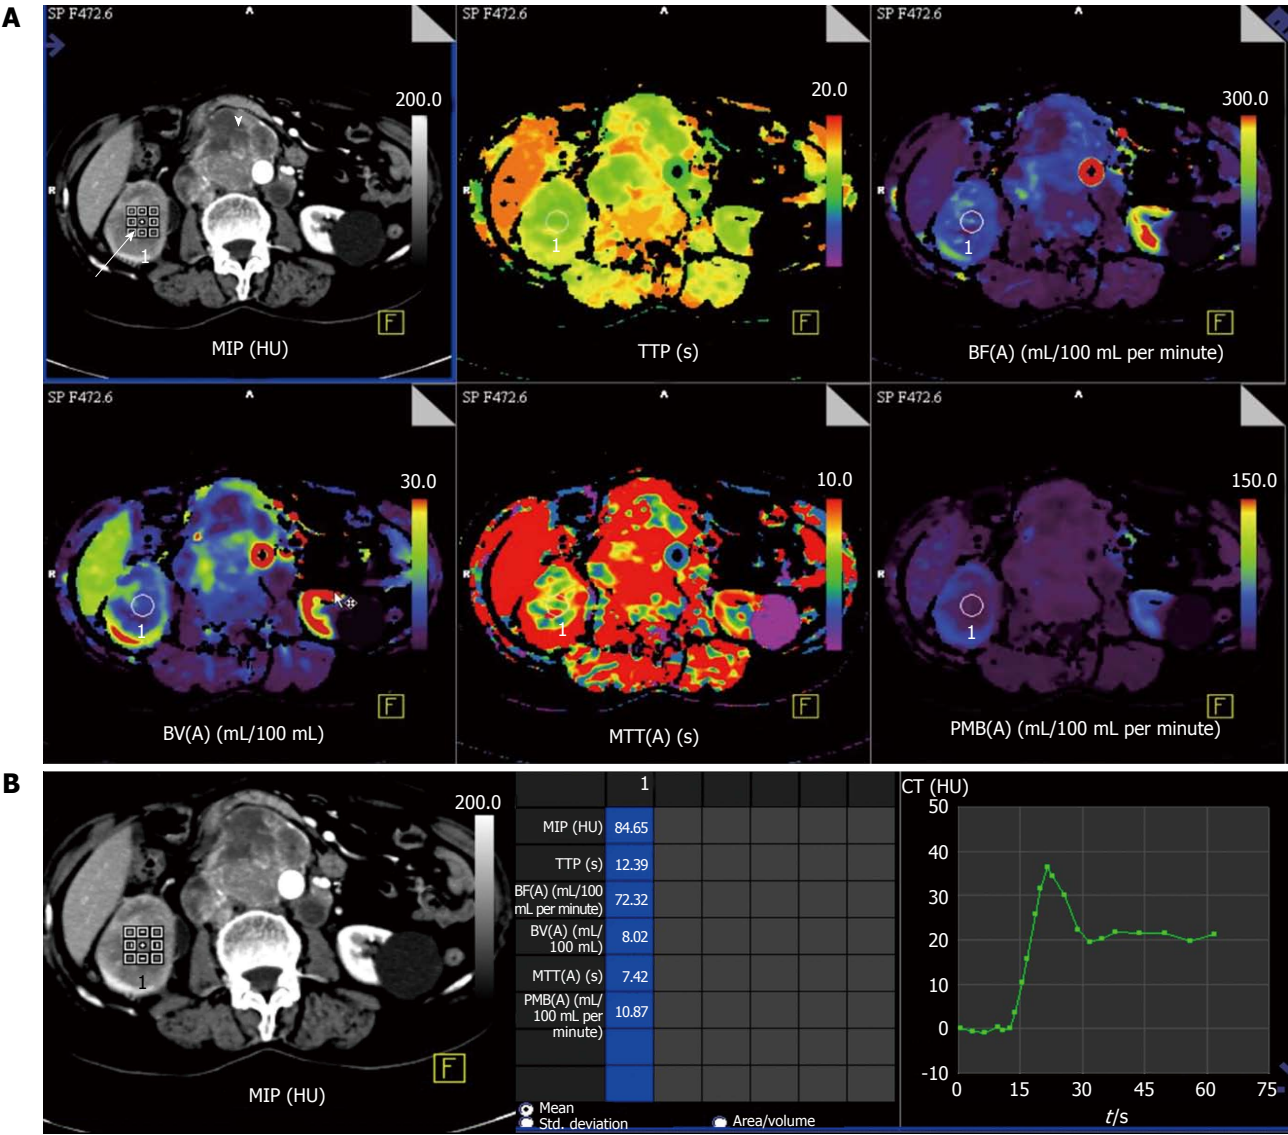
Perfusion computed tomography in a 63-year-old lady with right renal cell carcinoma (chromophobe type). A: Contrast computed tomography (CT) images show tumor in right kidney (white arrow) with retroperitoneal nodal metastases (arrowhead). Colour-coded perfusion maps show the perfusion parameters; B: Time attenuation curve and perfusion parameters with region-of-interest in the right renal cell carcinoma depict delayed wash-out of contrast. MIP: Maximum peak intensity; TTP: Time to peak; BF: Blood flow; BV: Blood volume; MTT: Mean transit time; PMB: Permeability.
